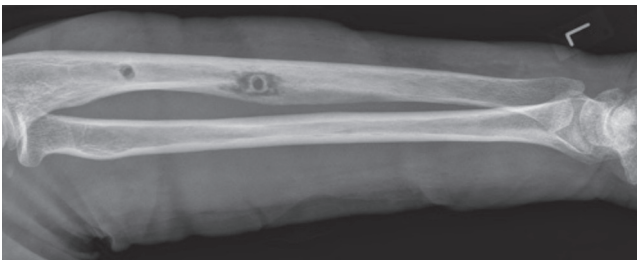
Risk of infection due to external fixation. The area of the former distal pin shows the radiographic signs of osteomyelitis.
